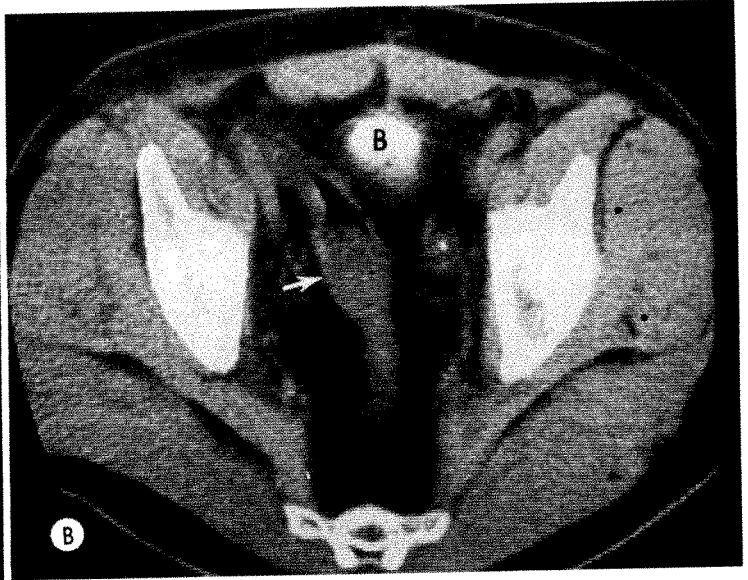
61-year-old man with vague abdominal pain. A. Barium enema demonstrating elevation of sigmoid colon out of pelvis; etiology uncertain (? mass, ? adhesion). Urogram normal. B. CT scan showing no evidence of mass surrounding sigmoid colon (arrow). Abundance of fat present within pelvis; bladder (B) filled with contrast media. CT findings obviated need for further diagnostic workup of questionable pelvic mass.
